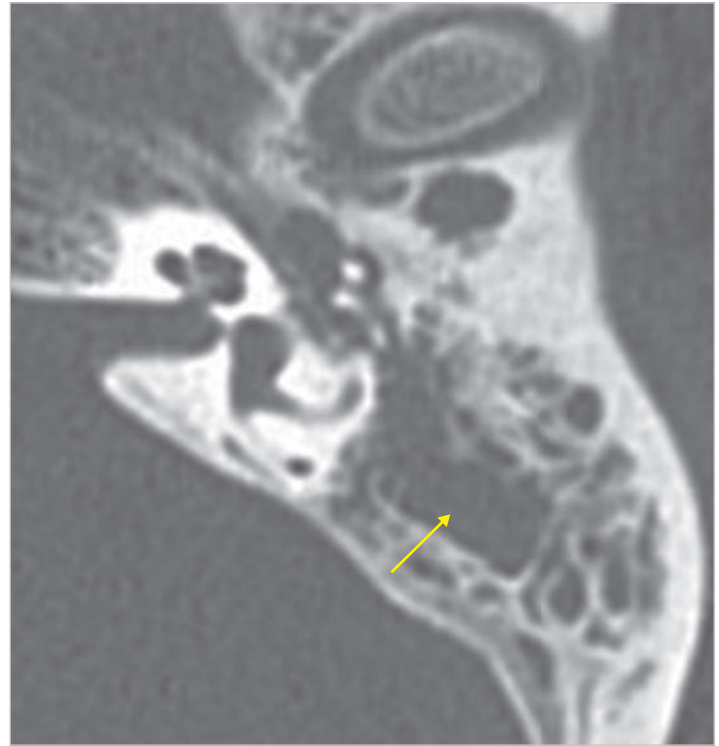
CT scan of the same patient, axial view. The opacification filling the mastoid is seen (*arrow*). It is not possible to differentiate between cholesteatoma and effusion in CT. Presence of cholesteatoma in the mastoid is verified during surgery.
